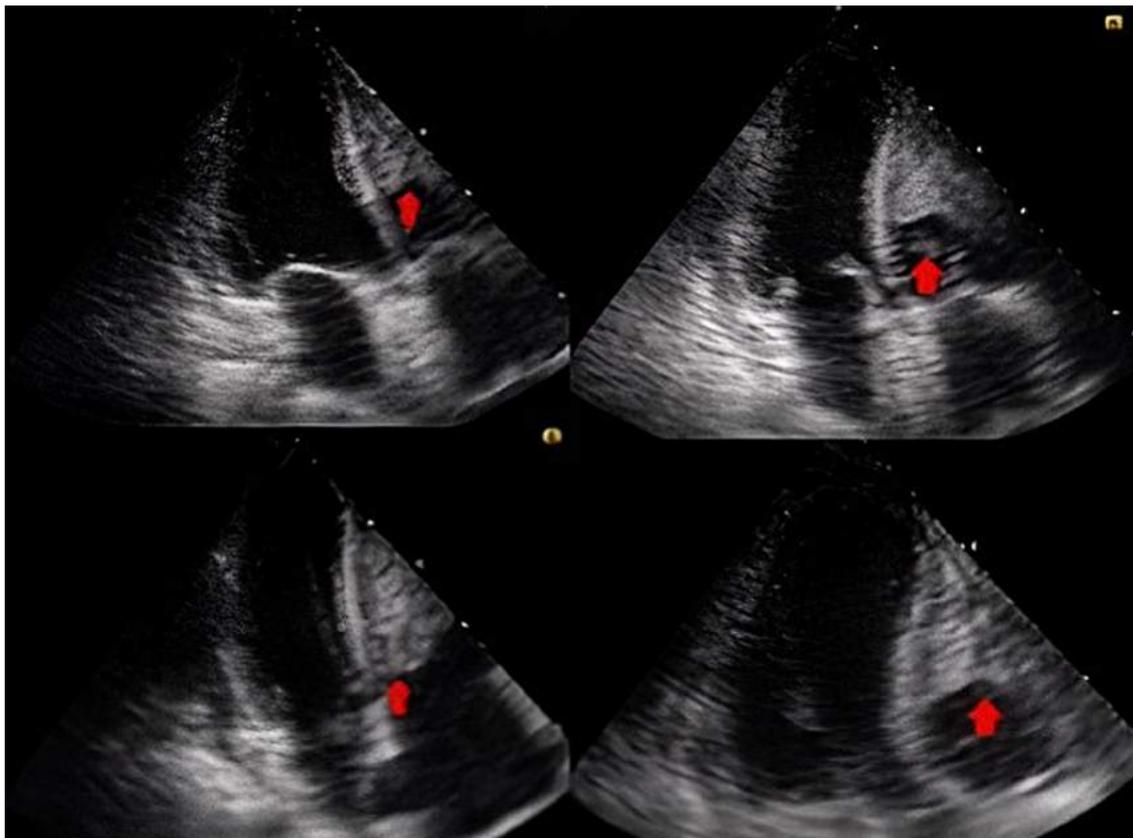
Transthoracic echocardiogram showing a thrombus covering most of the free wall of the right ventricle with another image of the same echogenicity, rounded, 1.6 x 1.6 cm, which oscillated and even protruded through the tricuspid valve. Courtesy of the radiology department, HORO.
